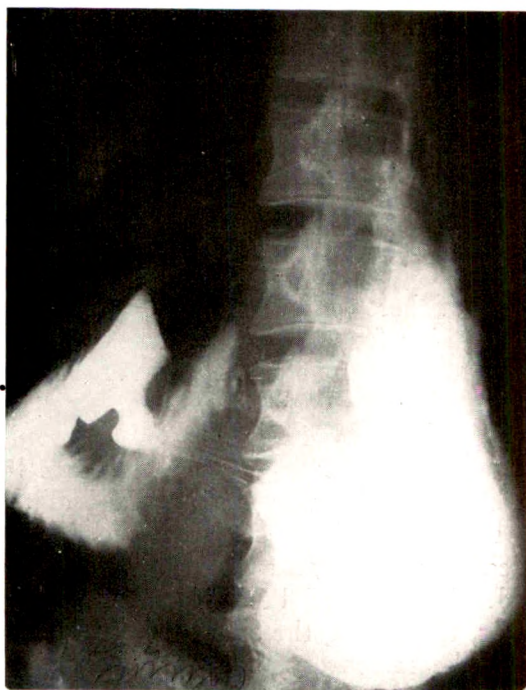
Roentgenogram showing gross defect in pyloric end of stomach.
